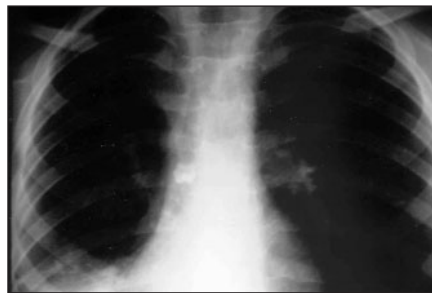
Anteroposterior chest radiograph showing a molar in the bronchus intermedium; atelectasis in the right-middle and lower lobe; and a mediastinal shift to the right.
